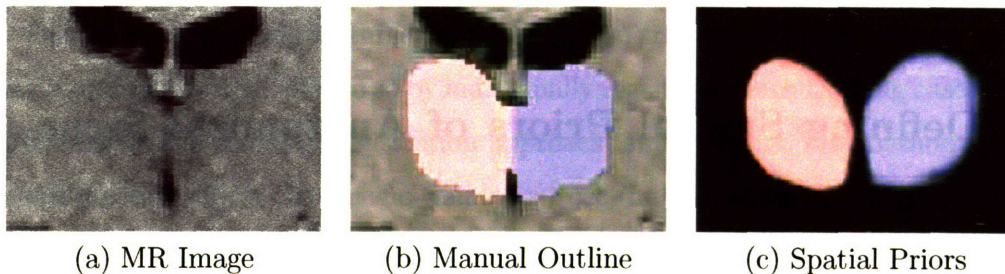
The MR image (a) shows the region around the thalamus. The corresponding segmentation (b) identifies the right thalamus as pink and the left thalamus as blue. In (a) the boundary of the thalamus is not clearly defined because it has a very similar intensity pattern to the neighboring white matter. The image in (c) shows the spatial priors of both anatomical structures with red indicating higher prior probability of the right thalamus and blue of the left thalamus. Spatial priors capture the spatial variation of an anatomical structure across a population. Many algorithms use them for segmenting structures with weakly visible boundaries.
